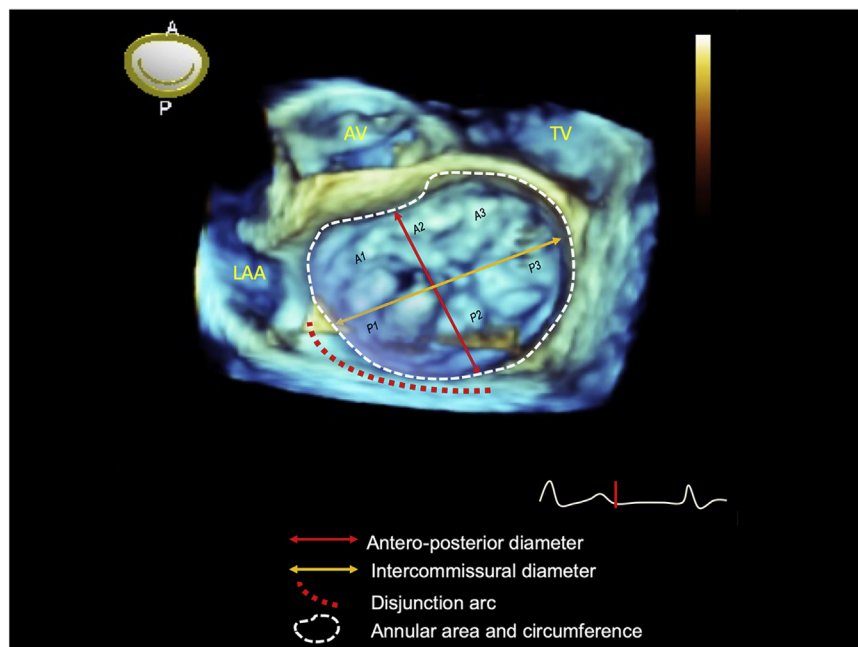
Three-dimensional evaluation of degenerative MV disease before mitral repair. Intraoperative 3D transesophageal echocardiographic reconstruction of myxomatous MVP for comprehensive dynamic analysis of the mitral annulus and MV leaflets. Note the posterior disjunction arc associated with enlarged annular diameters (vs no disjunction). AV, Aortic valve; LAA, left atrial appendage; TV, tricuspid valve.
